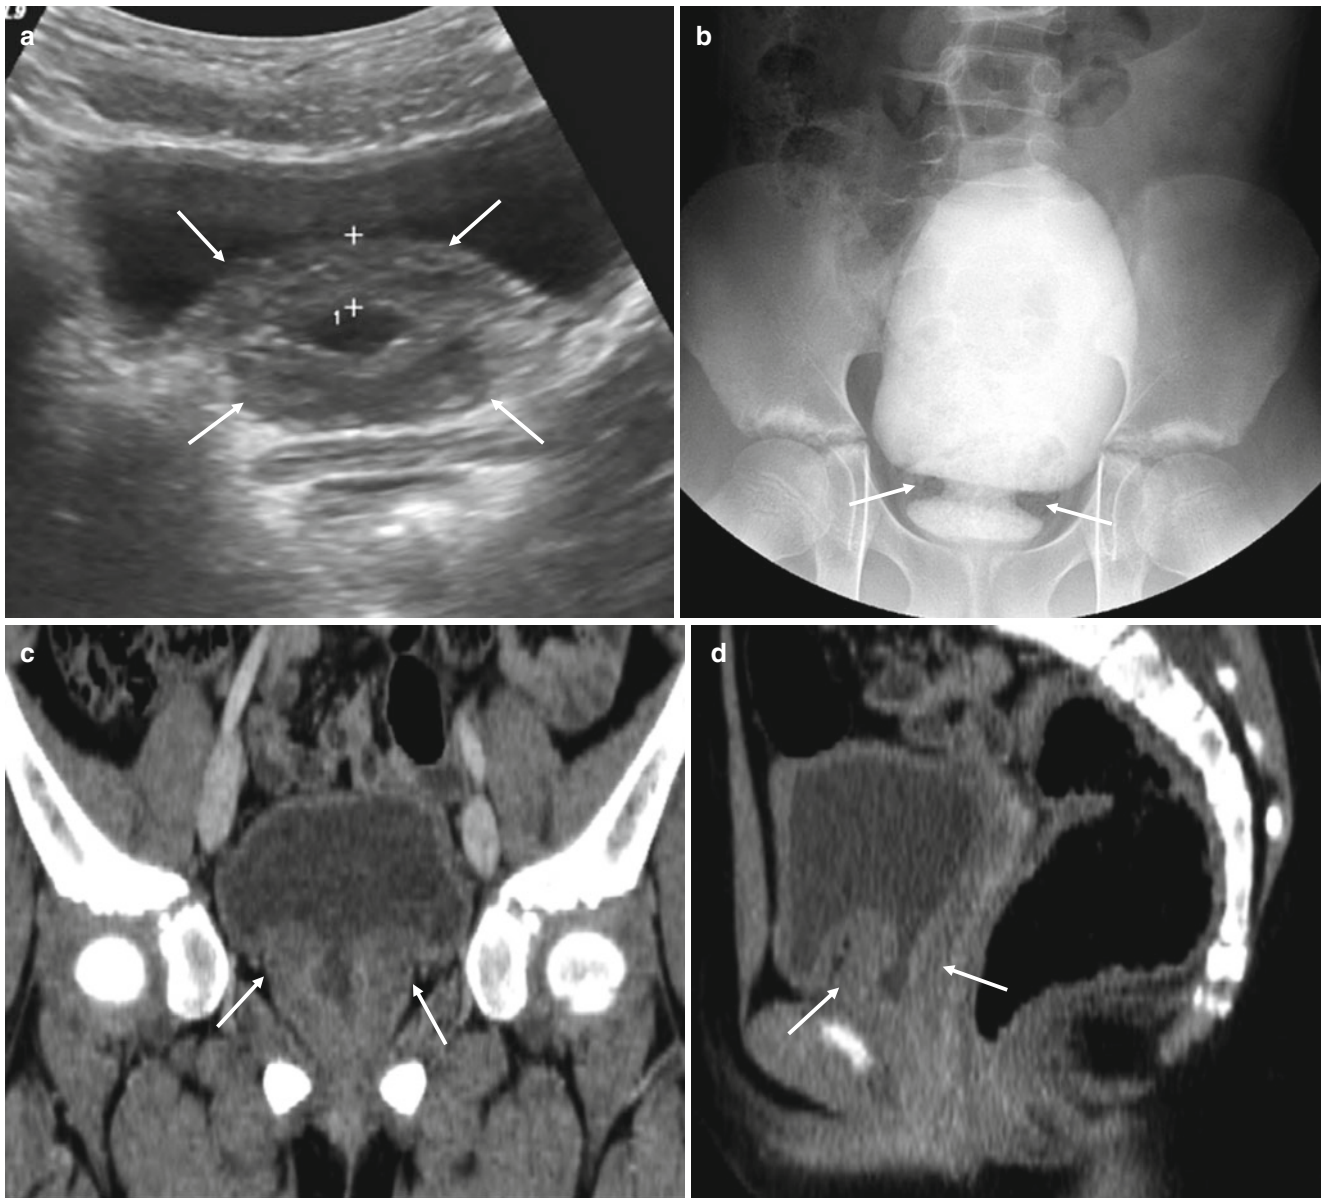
Cystitis cystica in an 11-year-old female. (a–d) Transverse US (a), VCUG (b), and contrast-enhanced CT images (c, d) show diffuse concentric wall thickening (arrows) at the bladder outlet. Bladder
